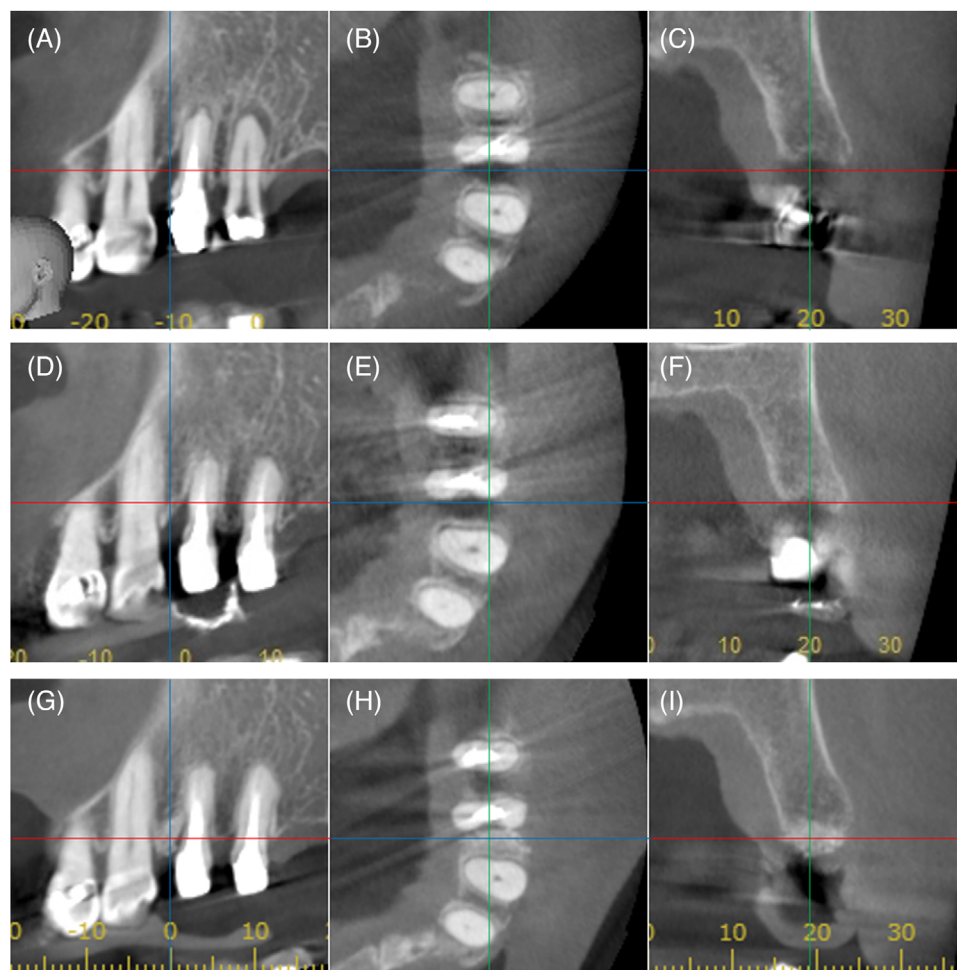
Comparison of baseline and 12 months postoperatively computed tomography (CT) images. CT images at first visit (A–C), baseline (D–F), and 12 months postoperatively (G–I). Sagittal view (A, D, G), axial view (B, E, H), and coronal view (C, F, I).
